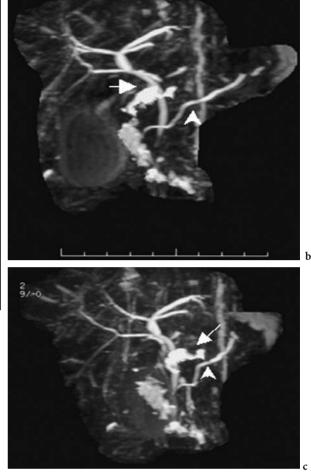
Pancreas divisum. a CT: distinctly seperate masses of pancreatic tissue. b,c MRCP: a slightly deformed part of the pancreatic head with the duct of Wirsung (*arrow*), as well as the rest of the pancreas containing the duct of Santorini (*arrowhead*)
